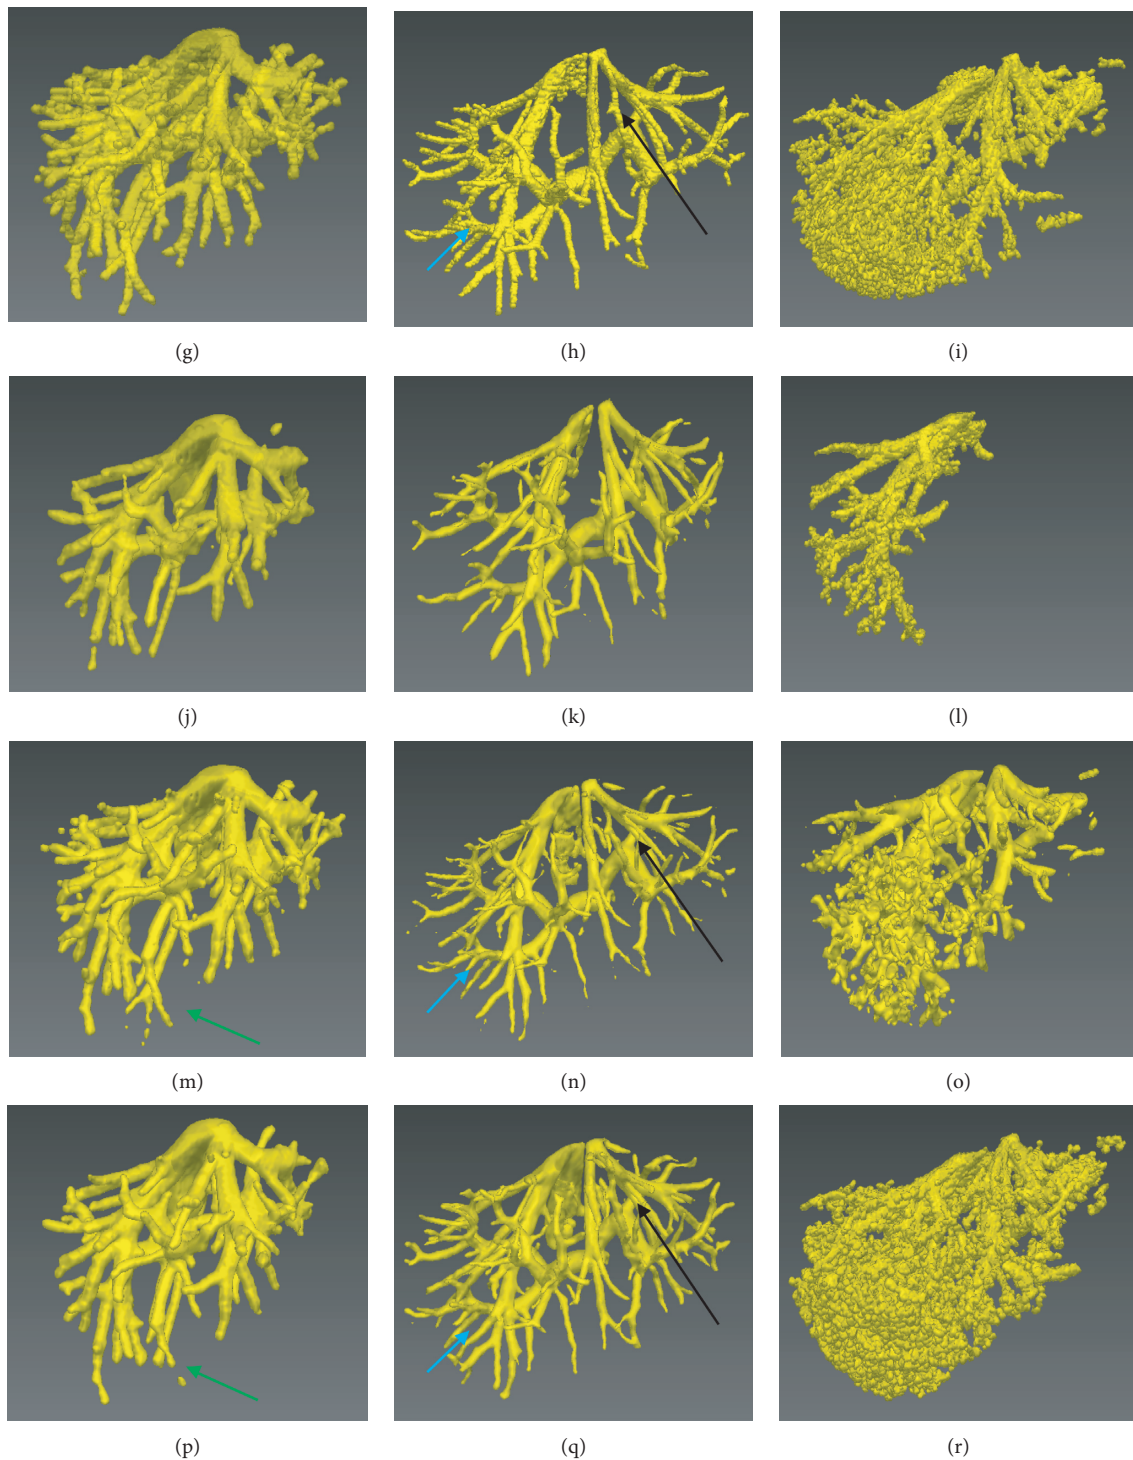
Comparison of the improved fuzzy connectedness (FC) method with traditional segmentation algorithms. Each column corresponds to one case. The original CT images of each case are shown in Figures 7(j)–7(r). (a)–(c) The gold standard of liver vessel. (d)–(f) The vessel segmented by using the improved FC. (g)–(i) The vessel segmented by using traditional FC with multiple potential seeds indicated by the blue points in Figure 2(b). (j)–(l) The vessel segmented by using traditional FC with one single seed indicated by the red point in Figure 2(b). (m)–(o) The vessel segmented by using region growing with multiple potential seeds. (p)–(r) The vessel segmented by using threshold level set with multiple potential seeds.
